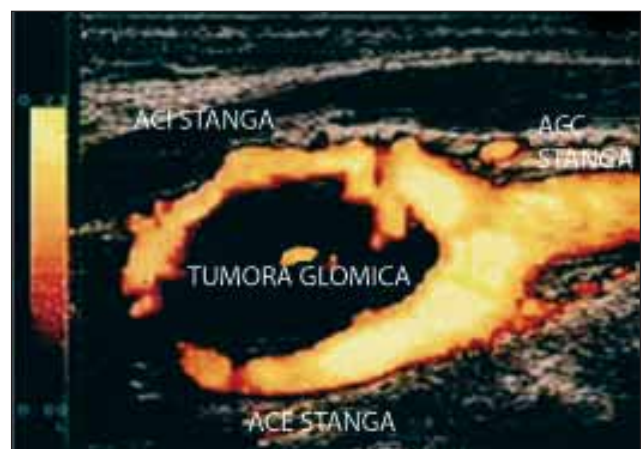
(first patient): glomus tumor of the left carotid body. Colour Doppler sonography: left cervical mass widening the carotid bifurcation
